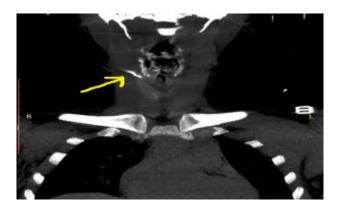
Computed tomography scan (coronal section) of the neck, post oral contrast, showing the sinus tract extending from the lower border of the ala of thyroid cartilage to the external opening on the neck.
